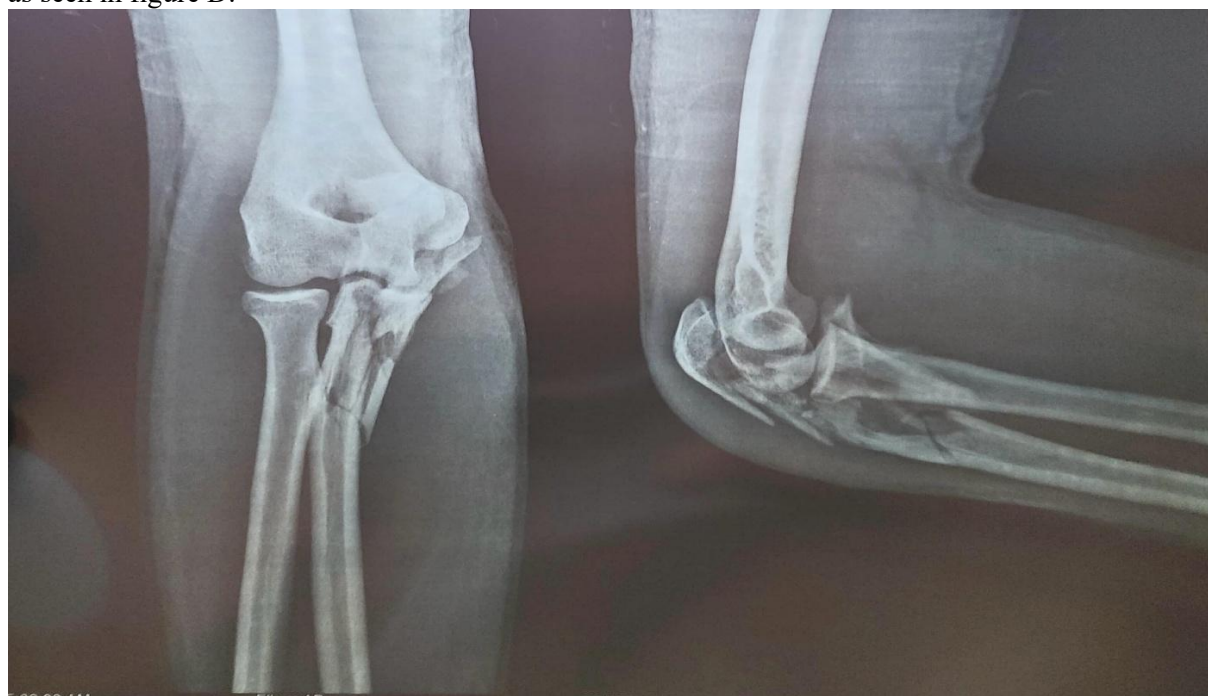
ap and lateral xray of right elbow showing comminuted proximal ulna fracture
